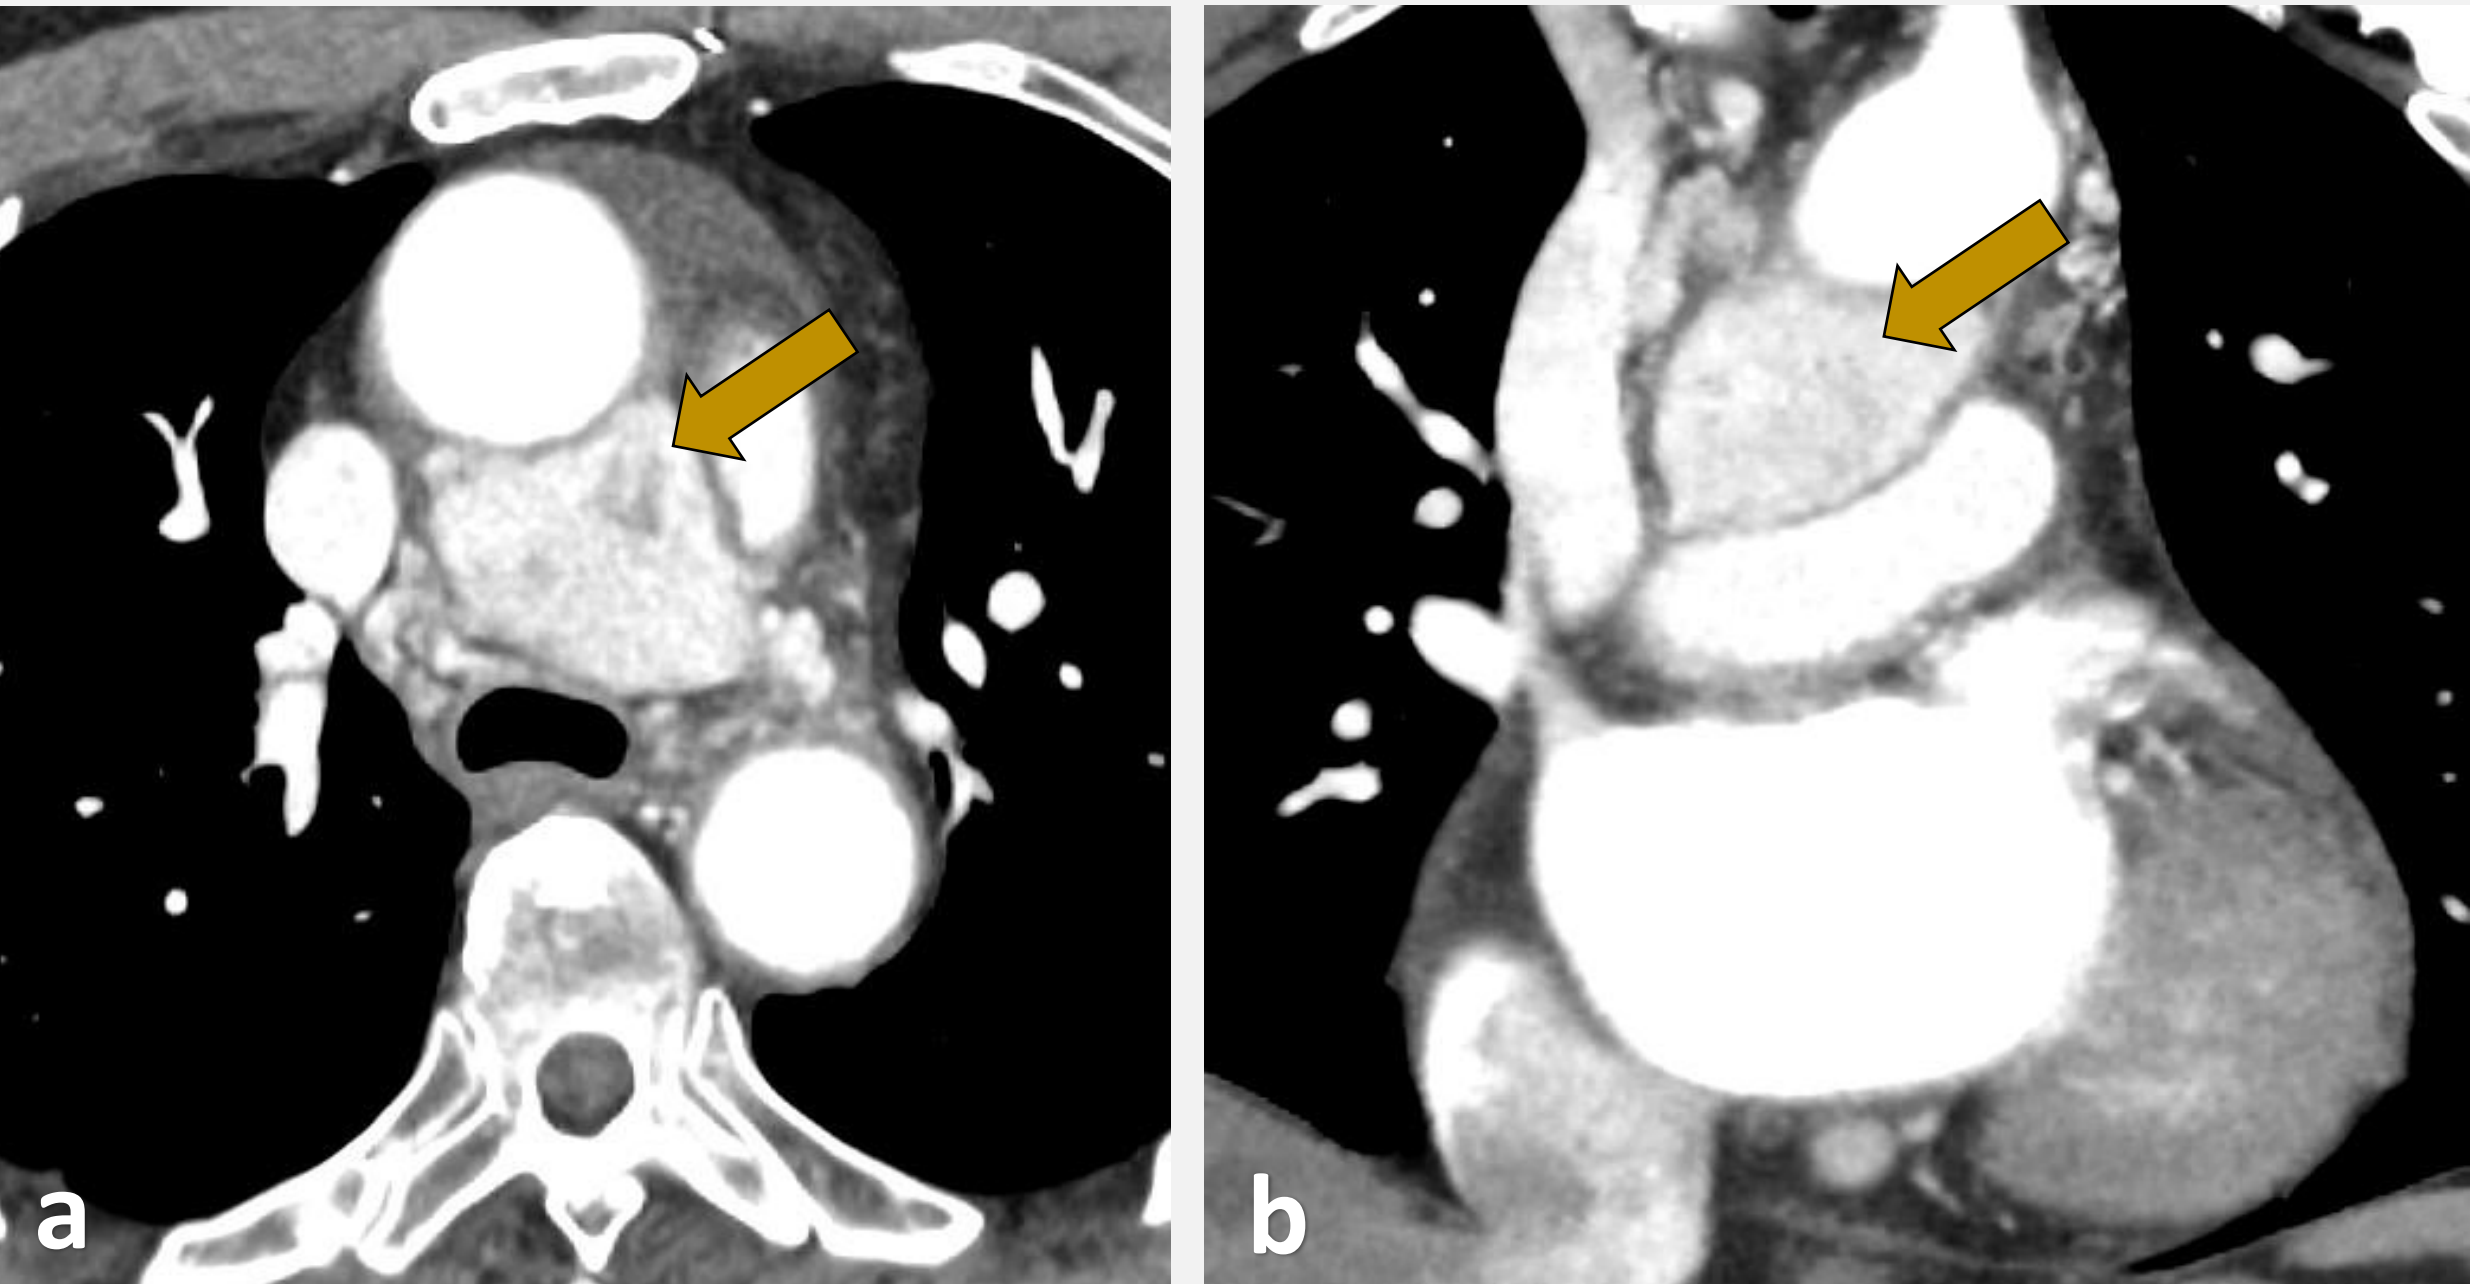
(a) axial and (b) coronal arterial-phase contrast-enhanced CT image.
